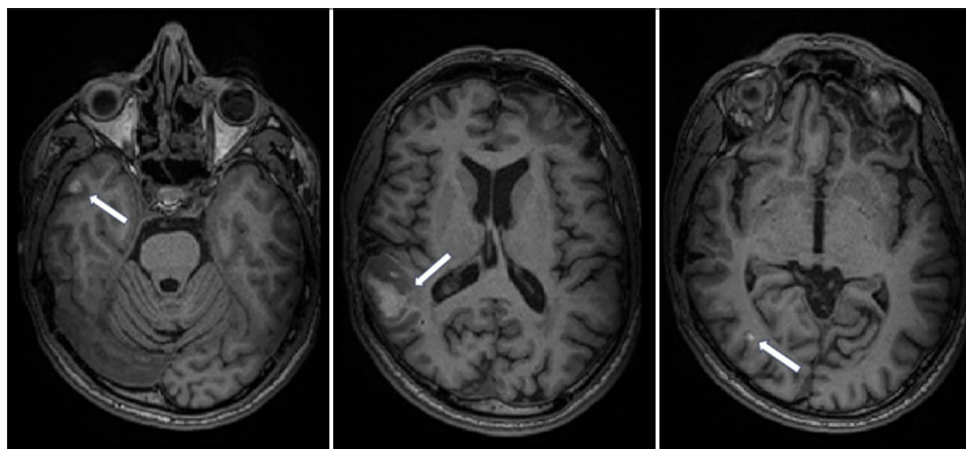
Axial T1MPRAGE from September 2024 demonstrating multiple subacute intracerebral hemorrhages (white arrows). T1-MPRAGE: T1-weighted magnetization-prepared rapid gradient-echo sequence
